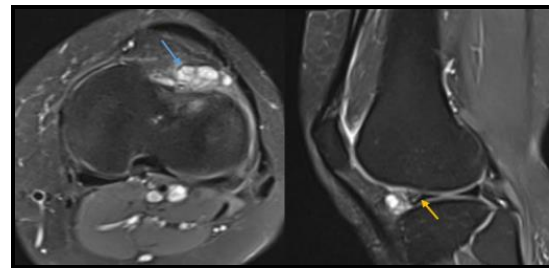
MRI findings: Lateral meniscal tear involving anterior horn and the (Yellow arrow), with small lateral Parameniscal cyst (blue arrow).
